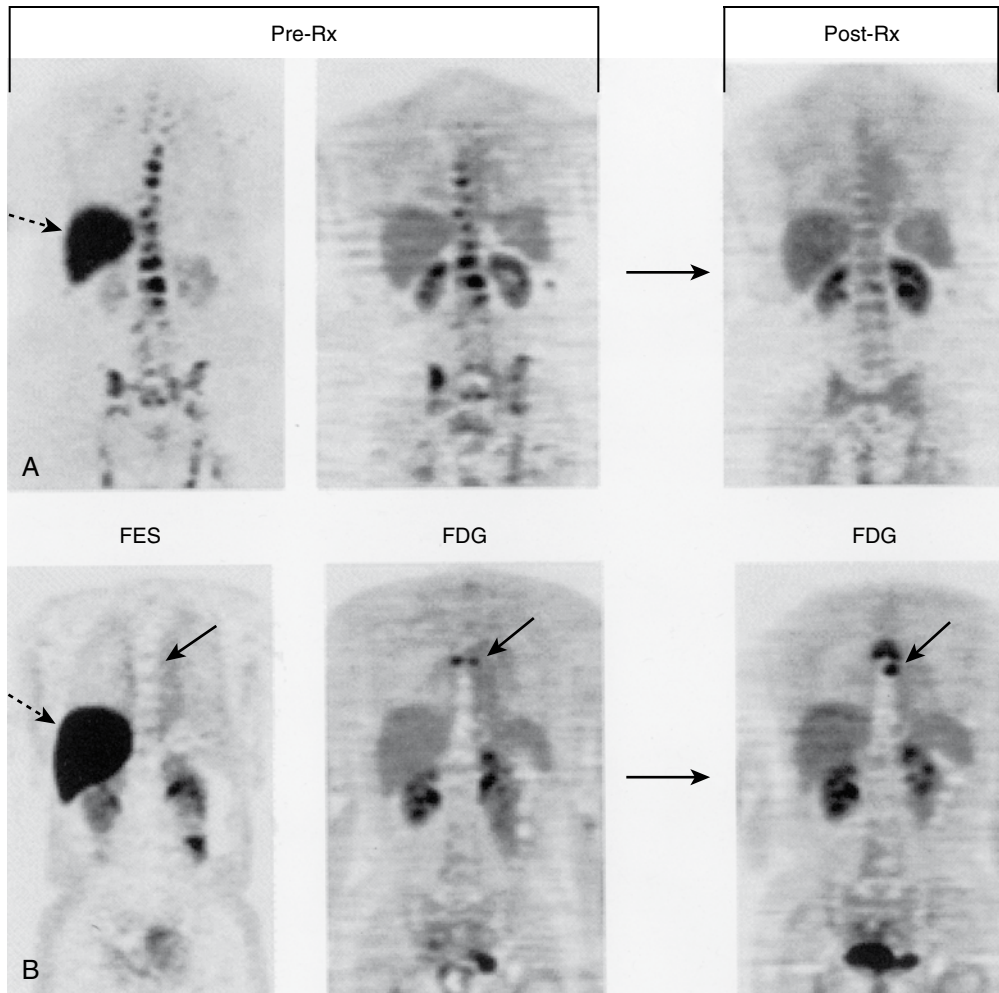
Positron emission tomography (PET) imaging of two patients with metastatic breast cancer before and after hormonal therapy. See text for details. FDG, ^{18}F -fluorodeoxyglucose; FES, ^{18}F -fluoroestradiol. (From Linden HM, Stekhova SA, Link JM, et al. Quantitative fluoroestradiol positron emission tomography imaging predicts response to endocrine treatment in breast cancer. *J Clin Oncol* 2006;24:2793–2799, with permission.)
